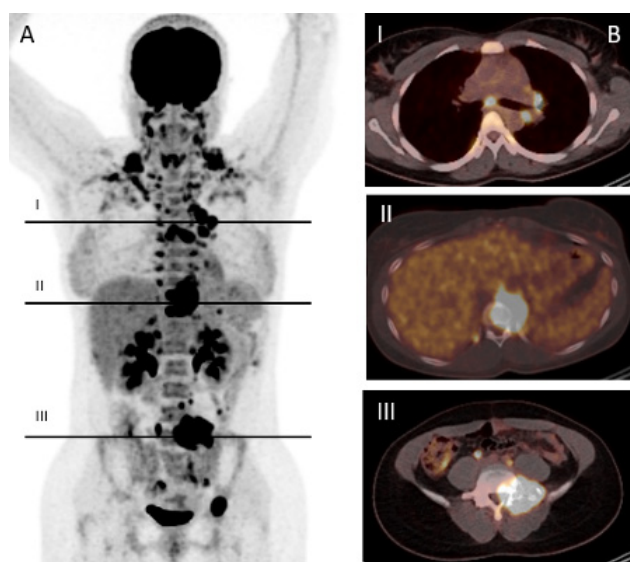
Case 2. A) The maximal intensity projection image and B) the corresponding fused ^{18}F FDG-PET/CT scan axial slices, show supradiaphragmatic and infradiaphragmatic lymphadenopathies along with multiple lytic bone lesions.
